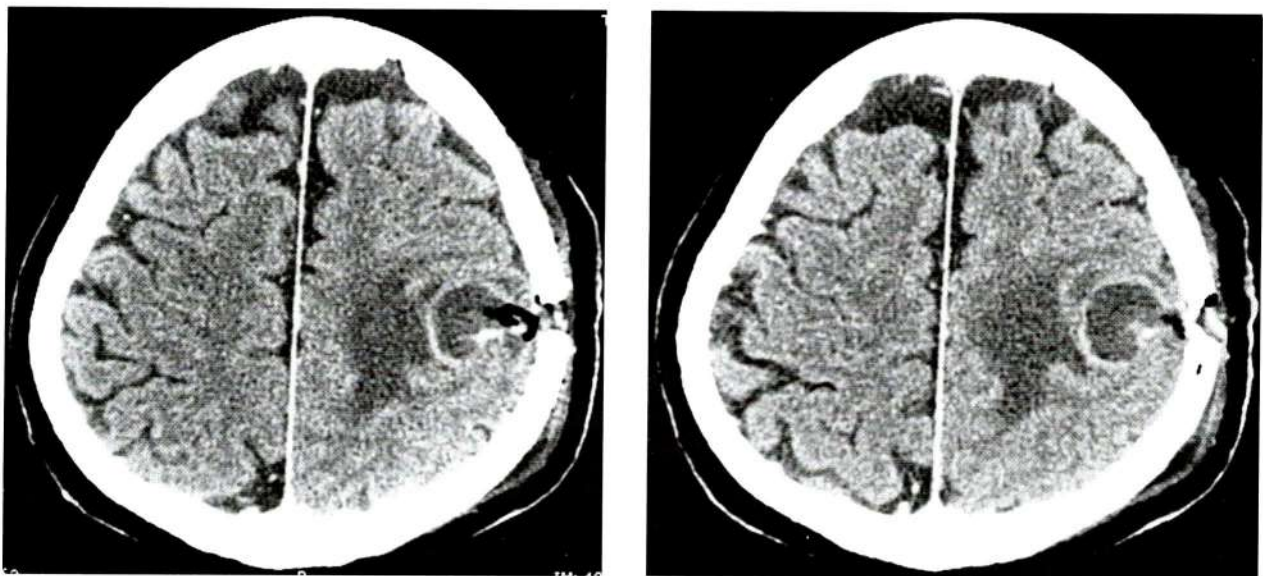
Follow up axial enhanced CT of the brain showed rim-enhanced lesion with persisted perilesional edema.
